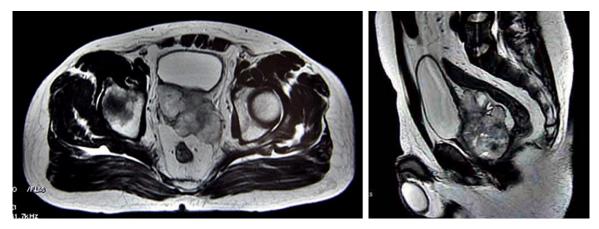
Magnetic resonance imaging showing 1) abnormal morphological appearance of prostate and seminal vesicles with mixed signal, 2) an enlarged prostate with expansive growth and compression of the rectum and bladder.
